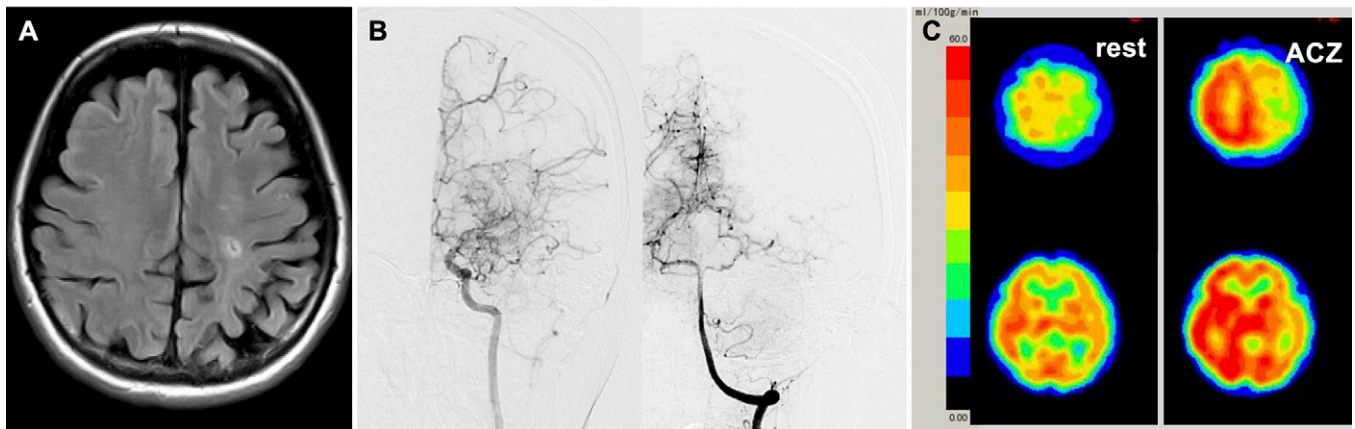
A: Preoperative fluid-attenuated inversion recovery imaging depicted a subcortical infarct in the left frontal lobe. B: Cerebral angiography showed severe stenosis in the terminal portion of the left internal carotid artery, MCA (*left*), and posterior cerebral artery (PCA; *right*) accompanied by abnormal vascular networks in the vicinity of stenotic lesions in the arterial phase, suggesting Suzuki angiographic stage III with PCA involvement. C: ^{123}I -IMP SPECT without (*left*) and with acetazolamide (ACZ) challenge (*right*) revealed decreased cerebral blood flow and cerebrovascular reserve in the left frontal lobe.
